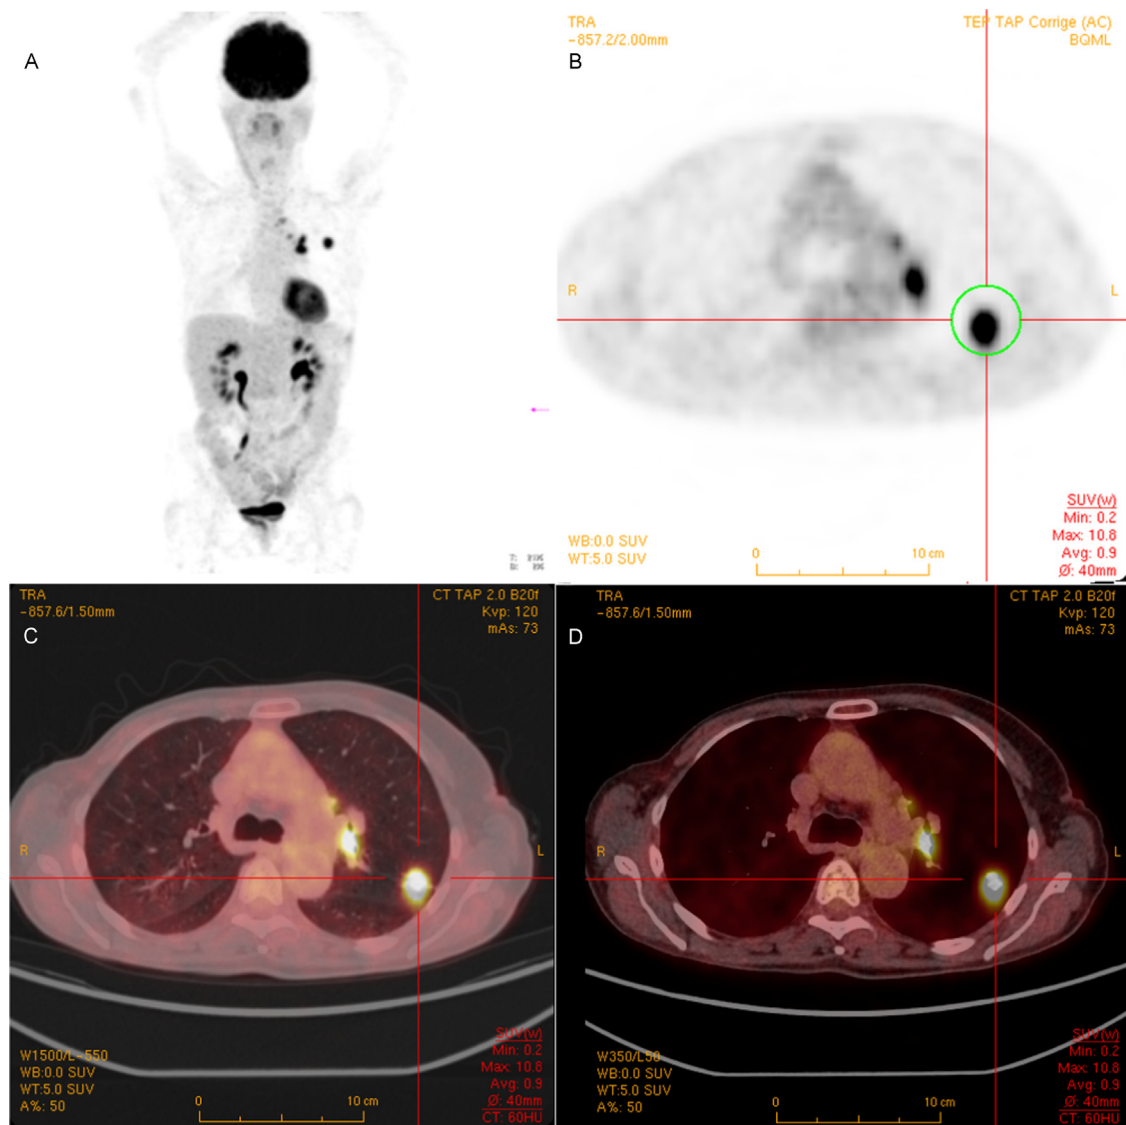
PET/CT images of glucose metabolism. (A) Maximum intensity projection image representing the whole-body bio-distribution of FDG. (B) shows an axial PET slice positioned on a lung lesion highlighted by the circled region. (C, D) show two fusion images obtained with two different HU windows. (Courtesy of Doctor Khalil Bourahla from the Anticancer Paul Strauss Hospital, Strasbourg, France).
